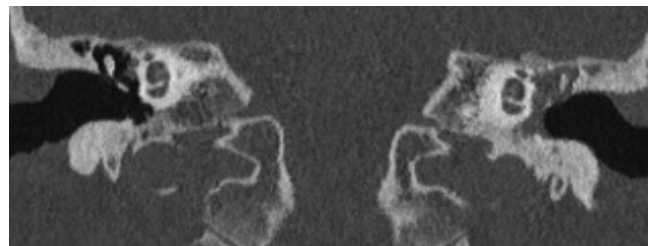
Coronal CT with left middle ear soft tissue opacification, with subtle lateral displacement and erosion of the ossicular chain compatible with pars tensa cholesteatoma.
